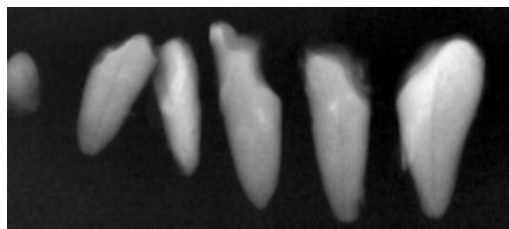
Radiograph after tooth extraction at 50 years of age. Stumps with no identifiable dental pulp and stumps with thread-like dental pulp are observed.
